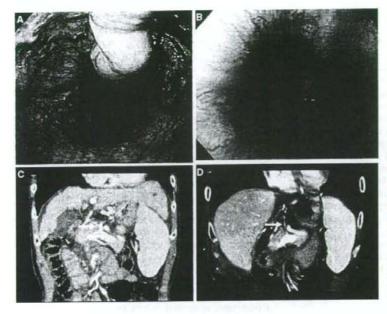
Endoscopic view of esophageal varices (EVs) demonstrating improvement after livingdonor liver transplantation (LDLT) (case 2). The form of EVs before LDLT was F3 (A) and improved to F1 at 12 month after LDLT (B). Narrowing of the left gastric vein was seen on multiplanar reconstruction images of multidetector computed tomography (MDCT) after LDLT. The diameter of the left gastric vein (LGV; arrow) in this patient was 15.4 mm before LDLT (C), and decreased to 5.9 mm at 7 months after LDLT (arrow) (D), with a rate of reduction of the LGV of 61.6%
